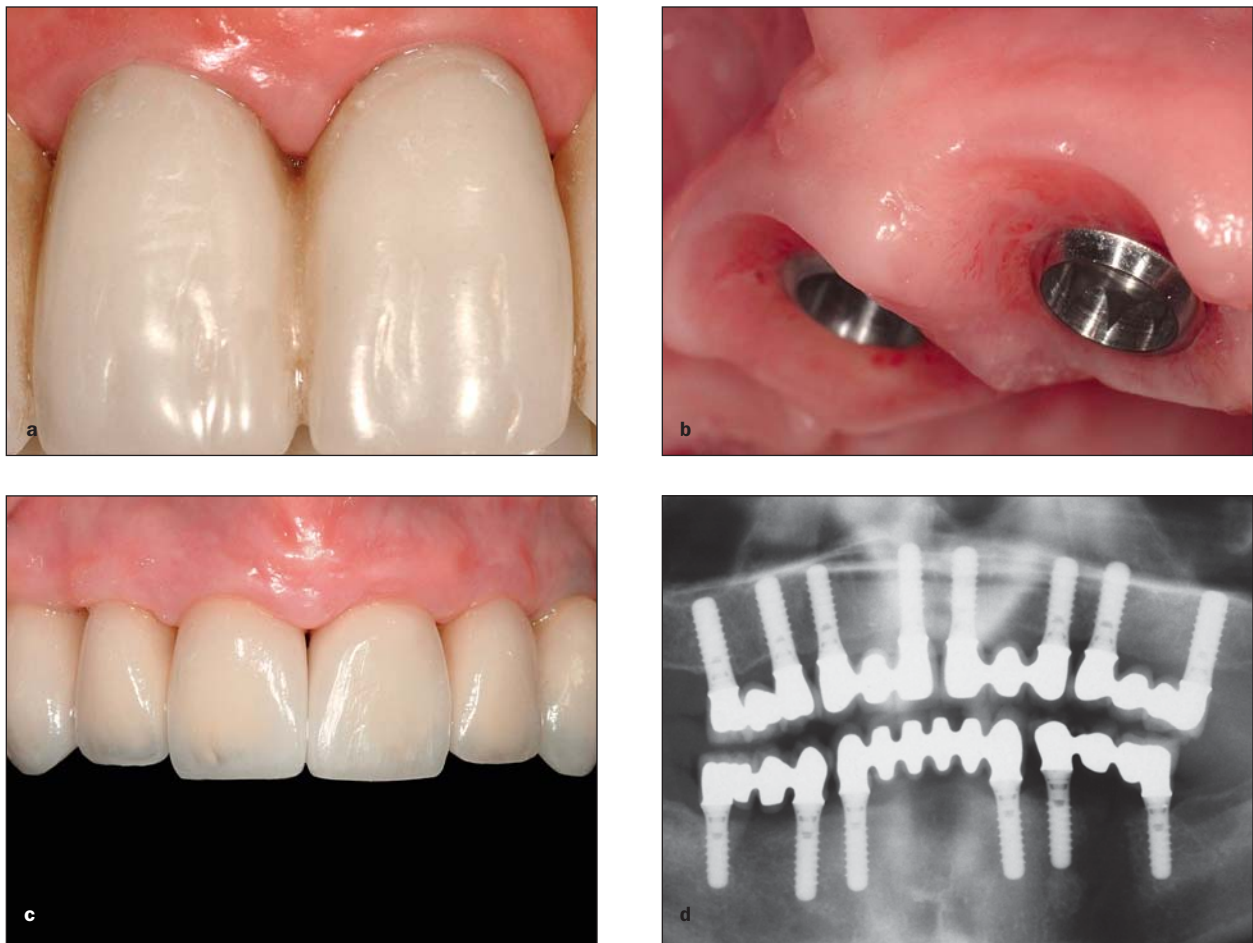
Clinical and radiographic status of definitive restoration, including scalloped peri-implant mucosa. (a) Frontal view of the immediate provisional restoration after 4 months of functional healing. The peri-implant soft tissue contour followed the cervical configuration of the provisional prosthesis. The mucosal level was apically displaced, whereas at interproximal level the papillalike mucosa occupied the embrasure space. This papillalike mucosa corresponded to the closest level of the original mucosa before treatment. (b) The peri-implant mucosa at the time of the posttreatment impression. After removal of the provisional prosthesis, the scalloped configuration of the mucosa and capillary vascularization of the peri-implant area could be observed. (c) Anterior image of the definitive ceramic restoration. The cervical configuration of the definitive restoration should ideally integrate with the previously reshaped peri-implant soft tissue. (d) Radiographic follow-up at seating of the full-arch segmented fixed restoration.
